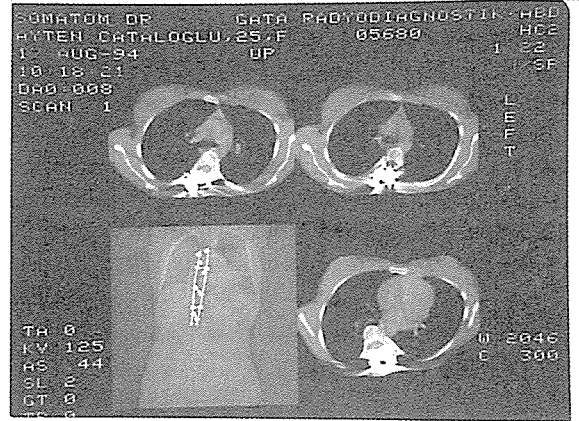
A.Ç. Postop. CT
